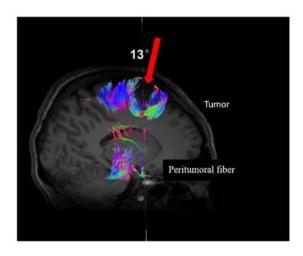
A 51-year-old female suffering from a laborious right foot raise was admitted to the Affiliated Hospital of Qingdoa University. The magnetic resonance imaging revealed lesions on the left side of the brain. Diffusion tensor tractography was performed to reconstruct the peritumoral fiber and indicated that the clear midline 13° angle was the safe surgical approach, with no damage to the peritumoral fiber. Following surgery, the muscle strength of the patient improved with no secondary neurological dysfunction. The red arrow indicates the tumor region.
